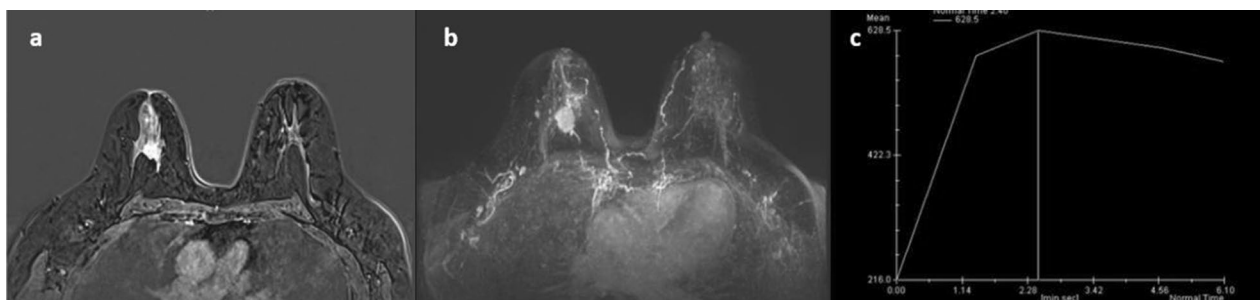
Rt. Breast pathologically proven invasive ductal carcinoma, NOS, grade III and luminal A type. ITGB 1 FC = 0.01. a T1 fat-suppression post-contrast subtracted images, b MIP images show an irregular, spiculated outlined soft tissue intensity focal mass lesion, seen at the mid-mammary region, and 12 o'clock area of the Rt. breast, about 37 mm from the nipple, measuring about $24 \times 19 \times 21$ mm, associated with anterior linear anterior intra- ductal extension. It displays intense heterogeneous enhancement at dynamic post-contrast study. c Type III-time signal intensity curve. Minimal Rt. sided nipple retraction is seen. Normal MRI appearance of the left breast
